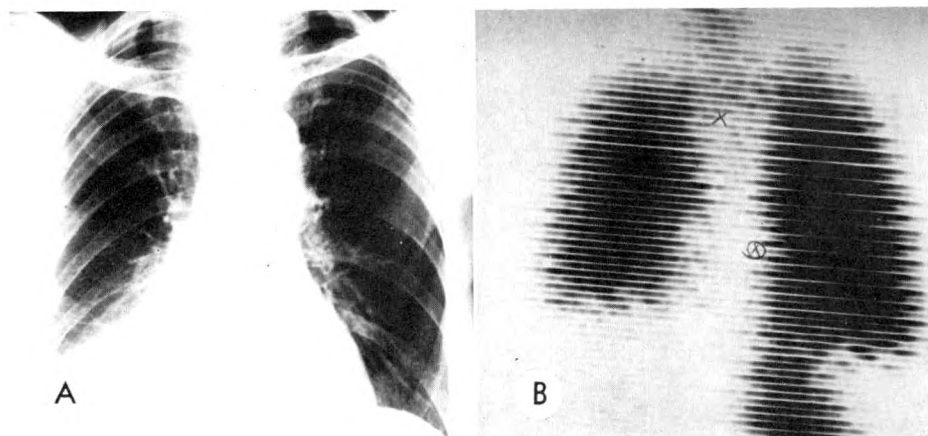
(A) Chest roentgenogram of a patient with right sided pleural effusion and right lower medial lung field pneumonia. (B) Ventilation scan of the same patient showing diffusely decreased ventilation of entire right lung (in prone position), marked decrease in radioactivity in the area of the pneumonia and retention of radioactivity in the stomach.
